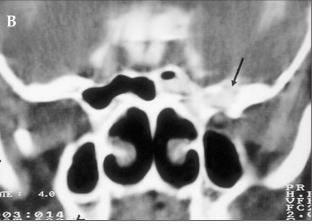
CT cisternography scan shows CSF tracking through the defect (black arrow) in the anterior portion of the lateral wall of the right sphenoid sinus
